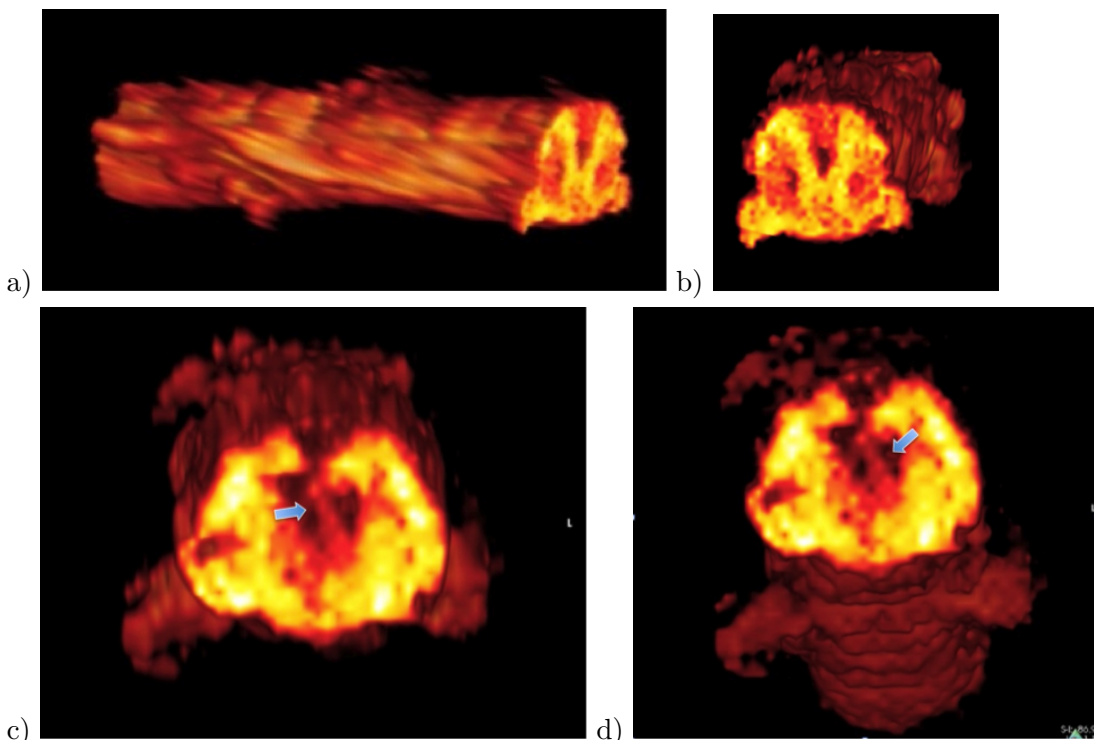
A) Dissected spinal cord MRI Reconstruction. B) Axial section, cephalic area of the lesion. C), D) Axial section of the injury epicenter, the arrow points to tissue growth through the implant.
